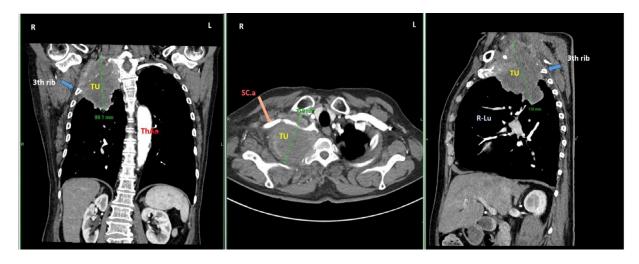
CT examination after 4 months: coronal, transversal, and sagittal section. Cl- clavicula, L-Lu – left lung, R-Lu – Right lung, SC.a – subclavian artery, Sca – scapula, ThAo- Thoracic aorta, Tr – trachea, TU – tumor, VB – vertebral body.
